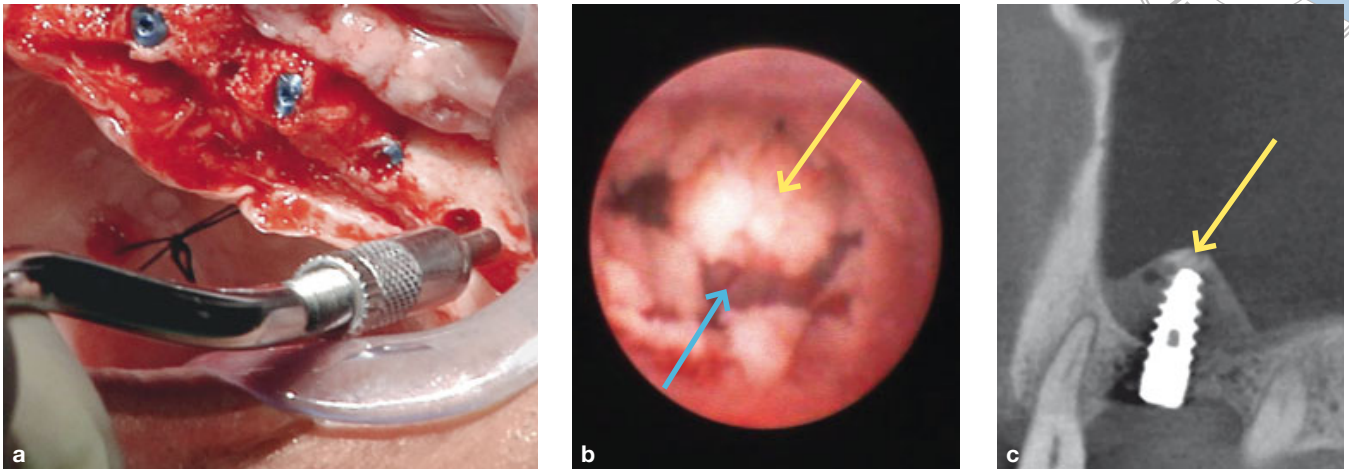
a The osteotome technique – preparation of the implant site with 2.7 mm curved osteotome. b Endoscopic view following the osteotome technique. The yellow arrow directed to the bony disk, the blue arrow directed to the Schneiderian membrane. c CBCT demonstrating the creation of the stable tent with the bony disk supported by the implant (the yellow arrow directed to the bony disk).
